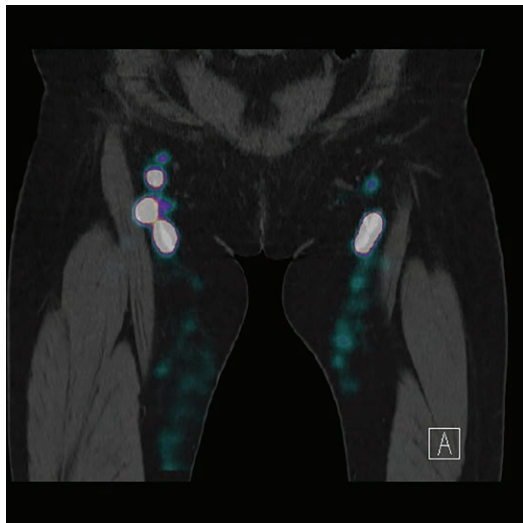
Preoperative lymphoscintigraph demonstrating location of sentinel nodes in the groin draining the lower extremity to guide laterality for node harvest.
